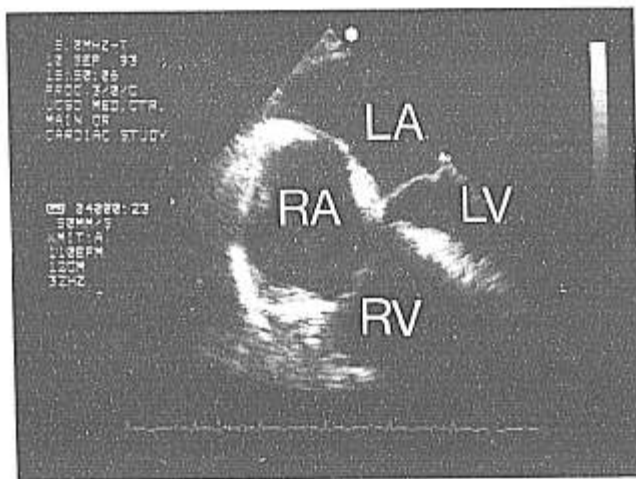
Transesophageal echocardiographic image (four-chamber view of heart) taken after the passage of the thromboembolus. RA = right atrium; RV = right ventricle; LA = left atrium; LV = left ventricle. One-centimeter intervals are indicated at the right margin of the screen.
